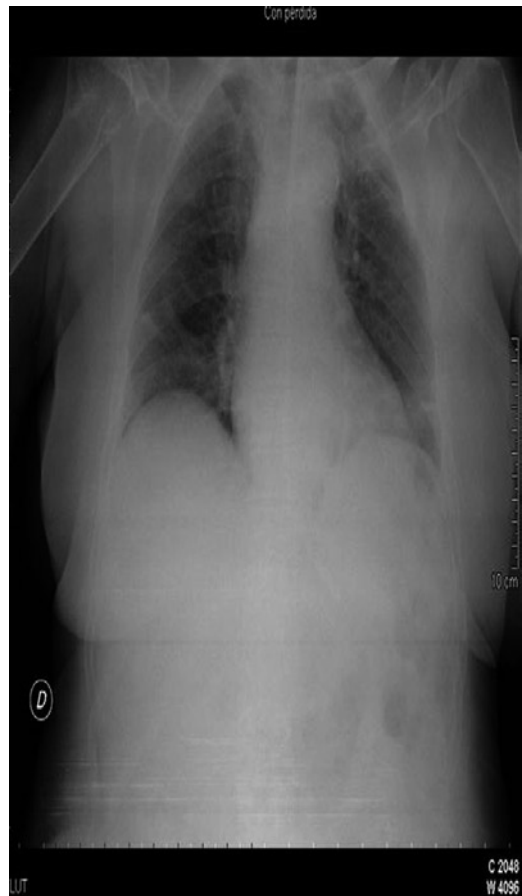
X-ray of chest with gastric tube feeding in situ. Copy of x-ray of chest with gastric feeding tube in situ. Correct position to ensure tube is in the stomach to prevent aspiration should be confirmed by x-ray prior to commencement of feeding
